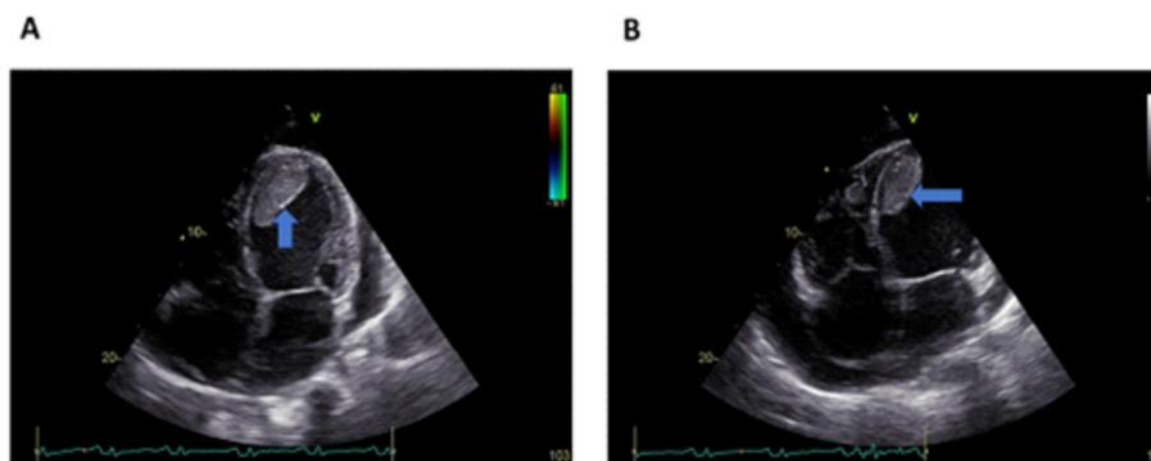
A. Apical four-chamber view echocardiogram of the index case with a huge thrombus in the apex of the left ventricle. B. Modified apical four-chamber view echocardiogram of the index case with a small thrombus in the apex of the right ventricle
